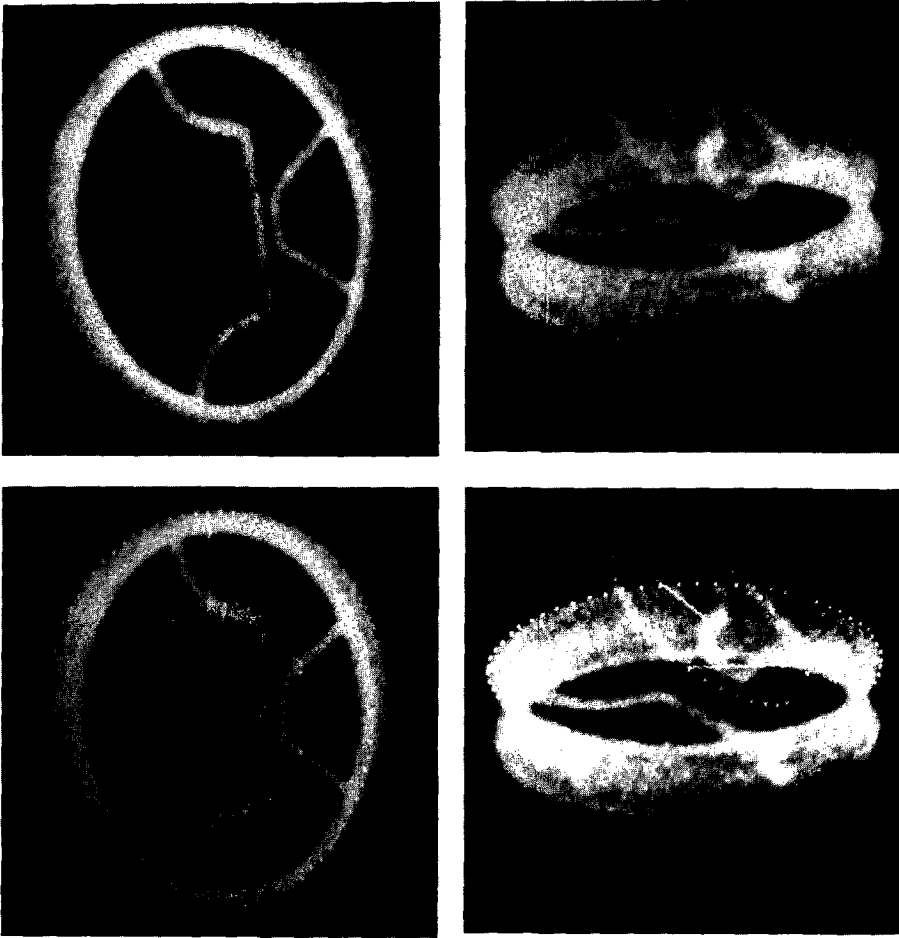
In the upper row two X-ray images of Björk-Shiley valves are shown from two projections. In the lower row, ellipsoidal dot images are adapted to the projections of ring and disc hoop, taking into account the thickness and rim of the metal valve ring.
